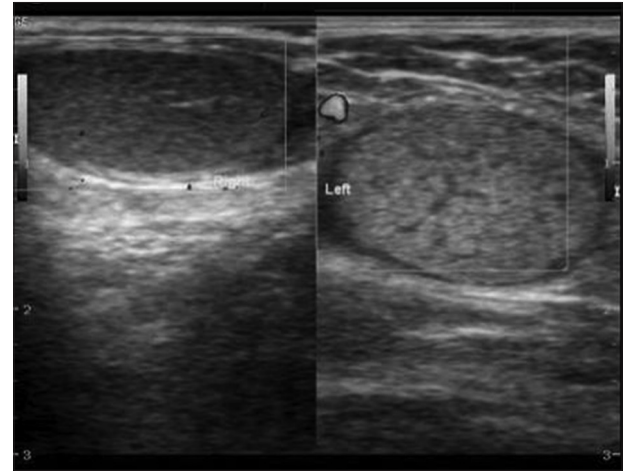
In Case 2, ultrasonography scrotum showing smaller right testis
